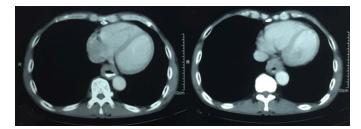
Contrast computed tomography showing circumferential lesion in lower esophagus.
